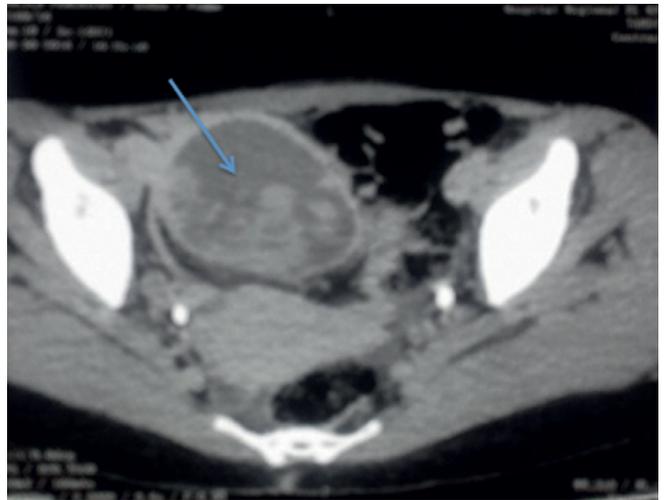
Abdominal and pelvic computed tomography scan showing a heterogeneous pelvic mass of 15 cm long axis, with dual component and significant contrast enhancement at the wall. Its origin was linked to the right ovary.
